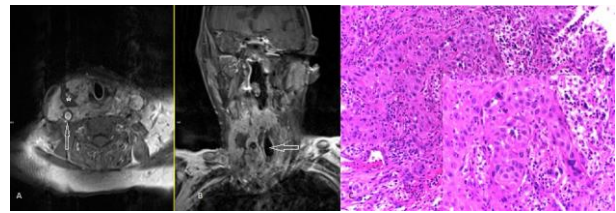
a. Axial MRI with contrast showed mass at right thyroid lobule. Asterisk: Necrotic component, Arrow: Common carotid artery surrounded by the mass. b. Coronal MRI with contrast showed the retrosternal progression of the mass. Arrow: Displaced and restricted trachea. c. Moderately differentiated squamous cell carcinoma in which some, but not all, of the neoplastic cells in nests have pink cytoplasmic keratin. High power of squamous cell carcinoma showed the presence of intercellular bridges. Mitosis can also be seen.
